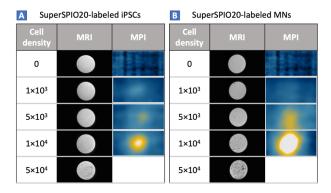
Comparison of MRI and MPI detection sensitivity for SuperSPIO20-labeled (A) iPSCs and (B) MNs. MPI has a 10-fold higher detection sensitivity.
